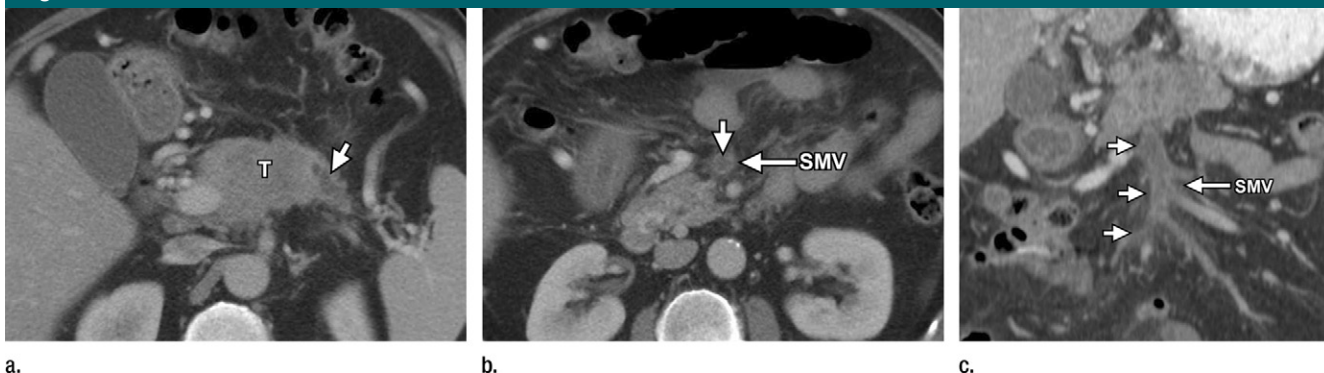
Images in a 55-year-old man with venous thrombosis. (a) Axial contrast-enhanced biphasic multidetector CT angiogram demonstrates a pancreatic body mass (T). Note the upstream dilatation of the pancreatic duct (short arrow). (b) Image at a lower level shows bland intraluminal thrombus in the SMV (short arrow). (c) Coronal reformatted CT image displays the extent of the thrombosis (short arrows).
